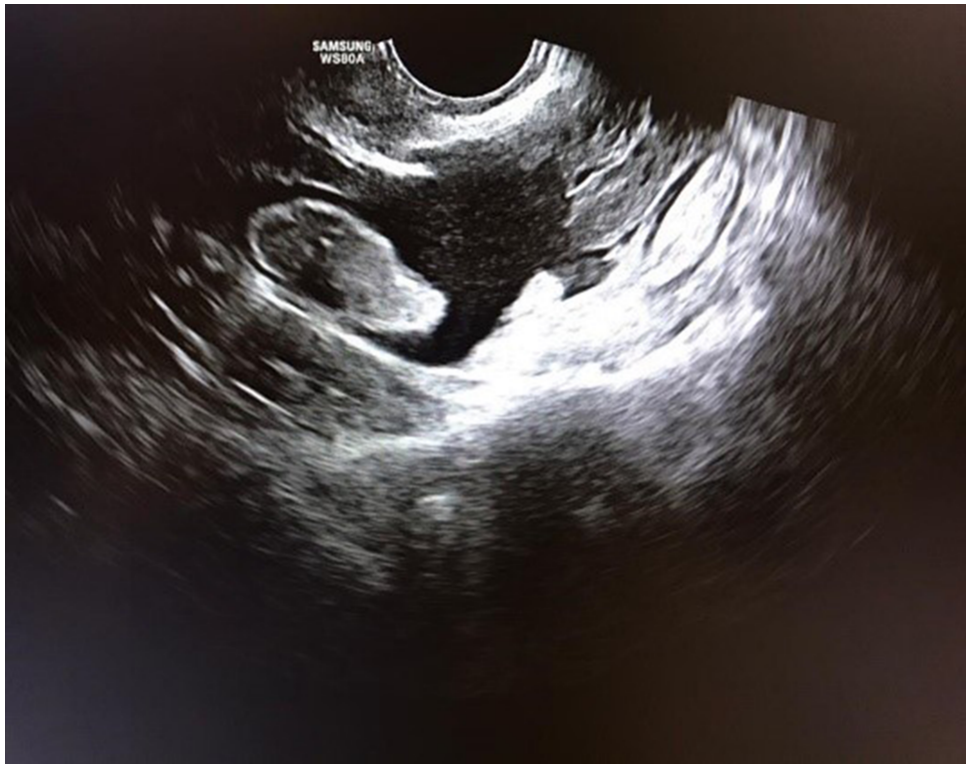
Ultrasound findings showing a 14 × 11 mm isoechoic ringlike lesion in the left adnexa, compatible with ectopic pregnancy
